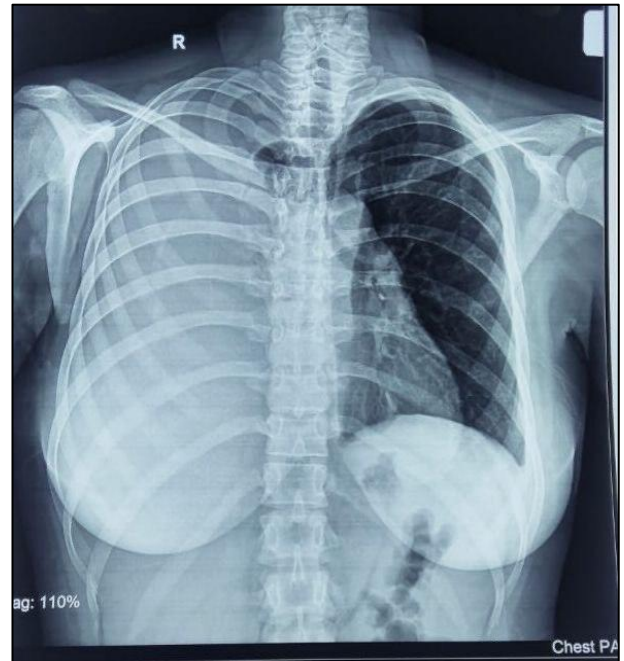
Chest X-ray suggestive of right massive effusion.
